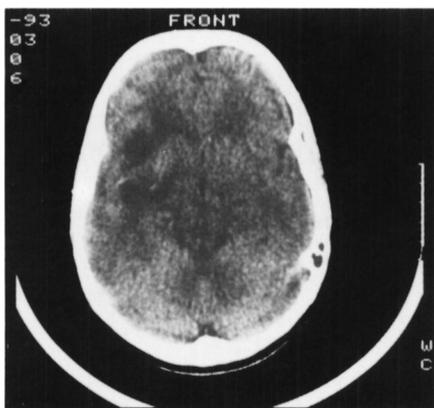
CT brain done 6 days after admission showing enhanced right temporal lobe lesion with oedema and small bleed.
